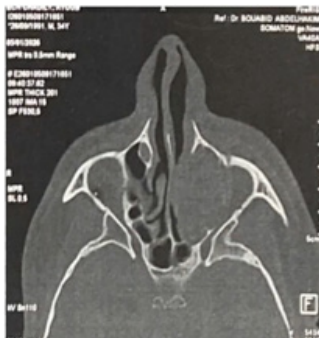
Axial CT scan showing a hypervascular expansile lesion occupying the left maxillary sinus with extension into the ipsilateral nasal cavity
